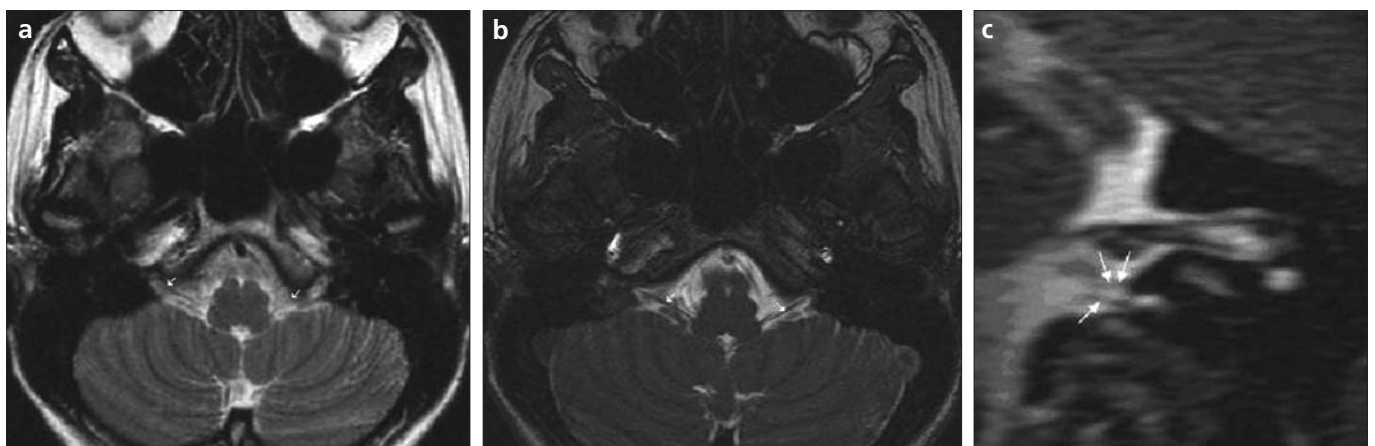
a–c. Cranial nerves IX–XI (lower nerve complex). On axial FSE T2W MR image (a) cranial nerves IX–XI cannot be clearly visualized (arrows). On axial (b, arrows) 3D FIESTA image MR and sagittal MIP reconstruction (c) of 3D FIESTA sequence, cisternal and foraminal parts of nerve IX (double arrow in c) and nerve X (single arrow in c) can be seen clearly. Nerve XI cannot be differentiated as a unique structure.
